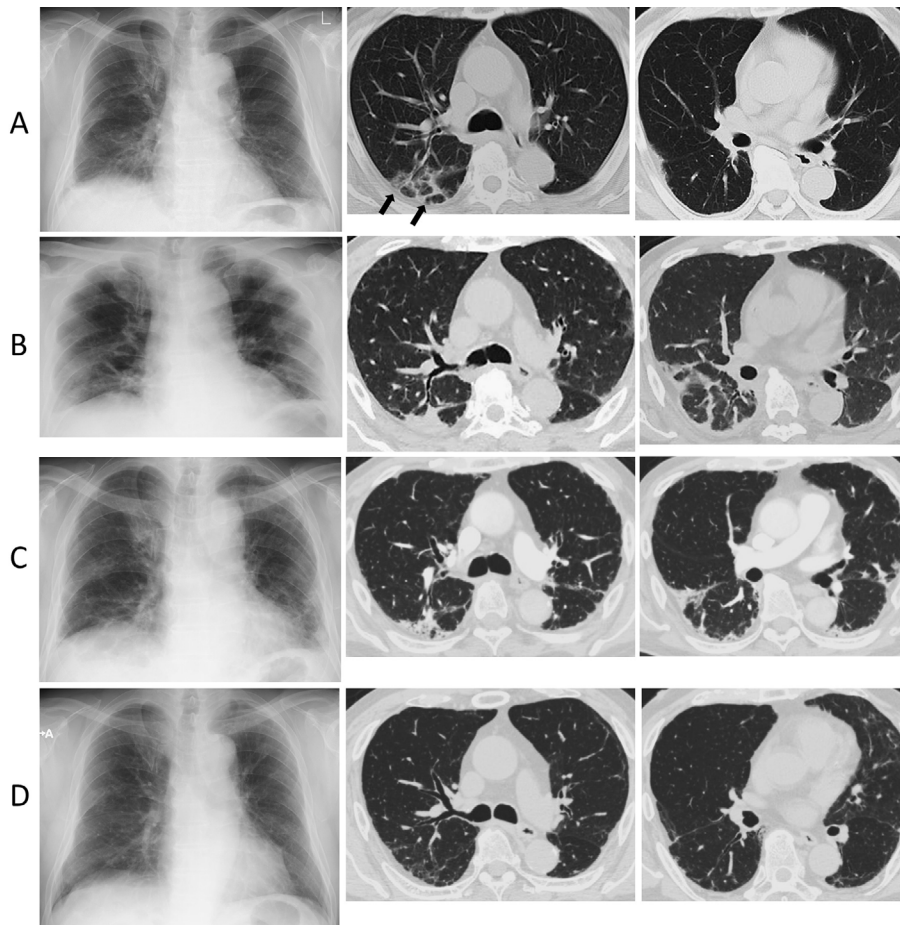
Chest radiography and high-resolution CT findings in Case 7. (A) Chest radiography on admission showed bilateral reticular shadow in both bases, whereas chest CT demonstrated peribronchovascular opacity with structured, poorly defined polygonal opacity (arrows). (B) The peribronchovascular opacity progressed to consolidation with a remarkable loss of lung volume in six days. (C) The loss of lung volume and consolidation were slightly improved 1.5 months after admission. (D) In the recovery phase, the consolidation decreased, and the loss of volume improved 15 months after admission.
